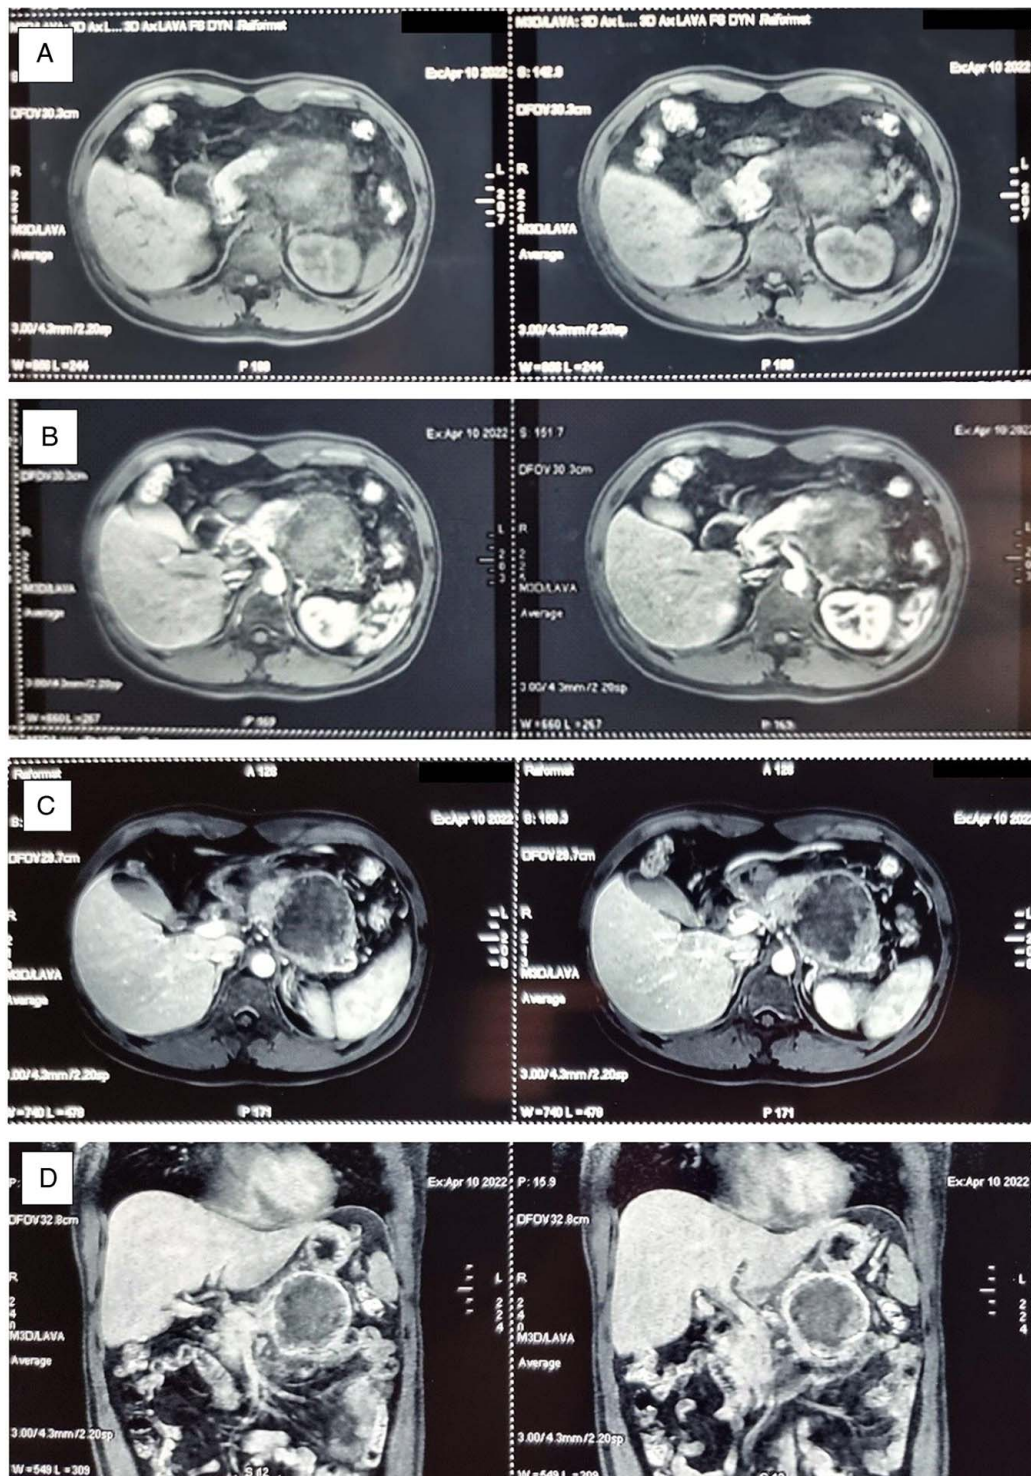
Axial pre-contrast (A) and post-contrast arterial phases (B) and axial (C), coronal (D) venous phases T1-weighted fat-suppressed; axial T2-weighted fat-suppressed (E). Further non-invasive and invasive tests show: a left-sided pancreatic tumour invading the splenic vein.
